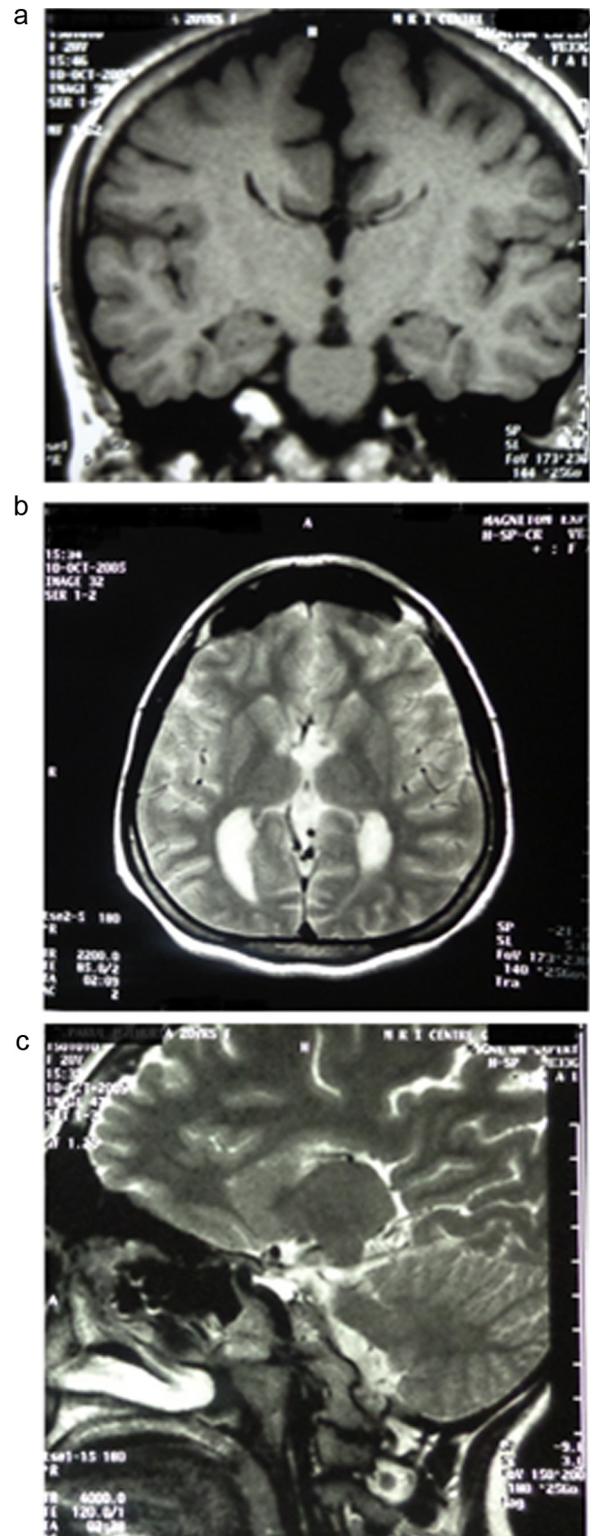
a–c: prestroke MRI revealing agenesis of the corpus callosum: a: T1 coronal; b: T2 axial; and c: T2 sagittal.
